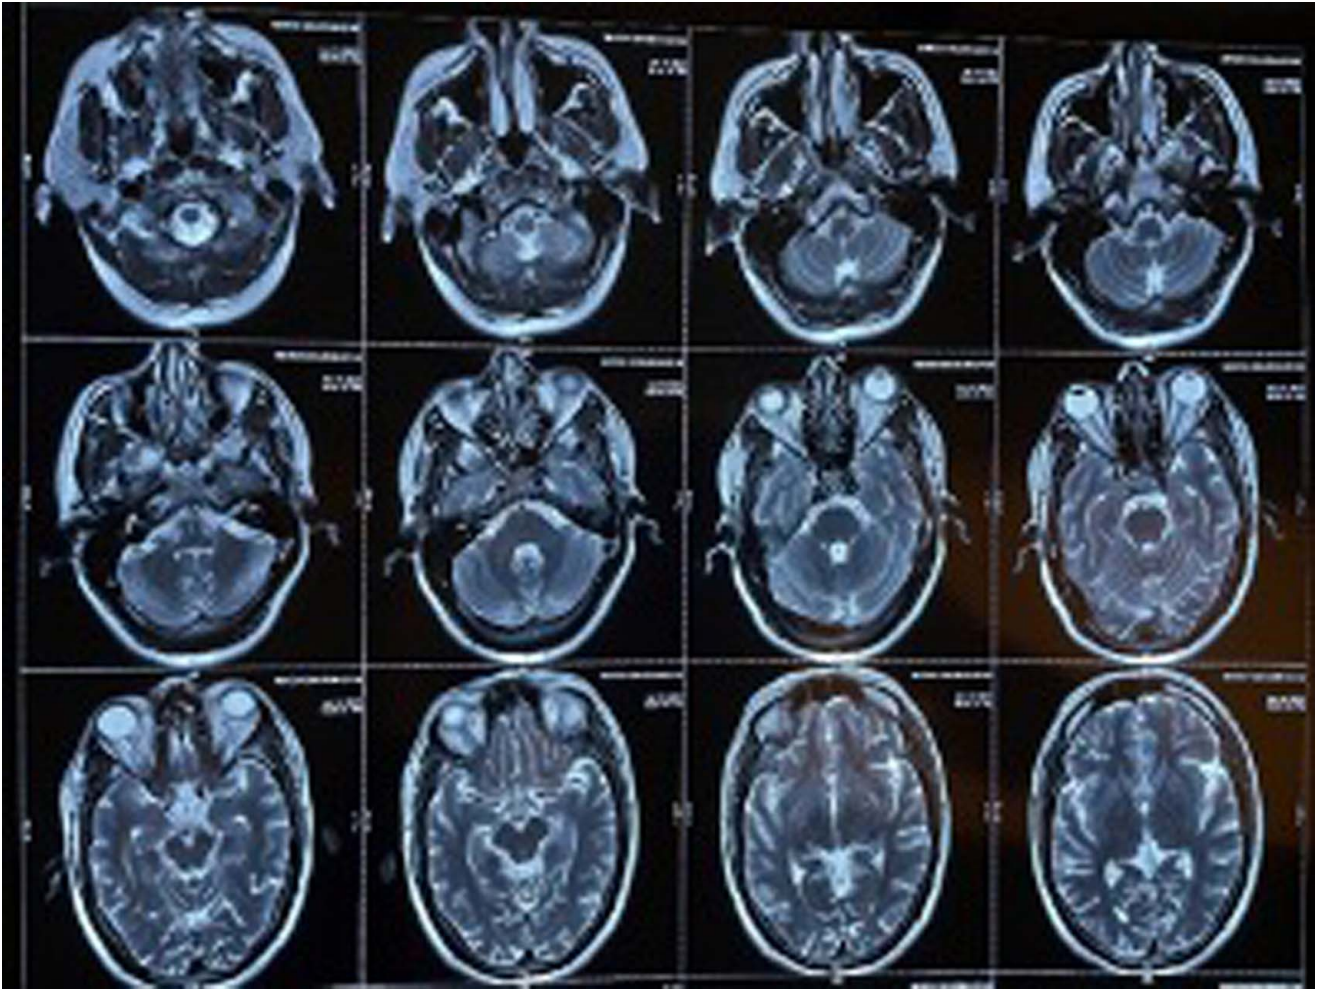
MRI showing thrombosis of cavernous sinus.
